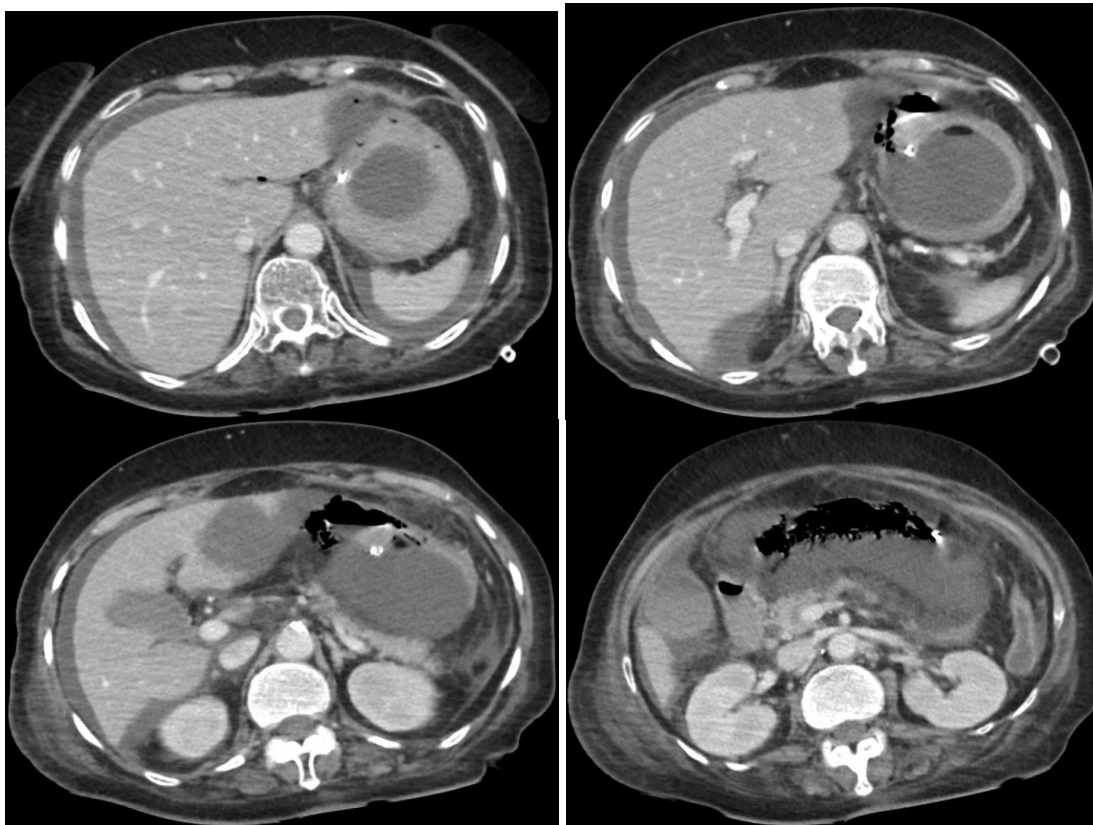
A computed tomography (CT) showing significant free fluid in the perihepatic area with increased abdominal fat stranding and gastric emphysema.
